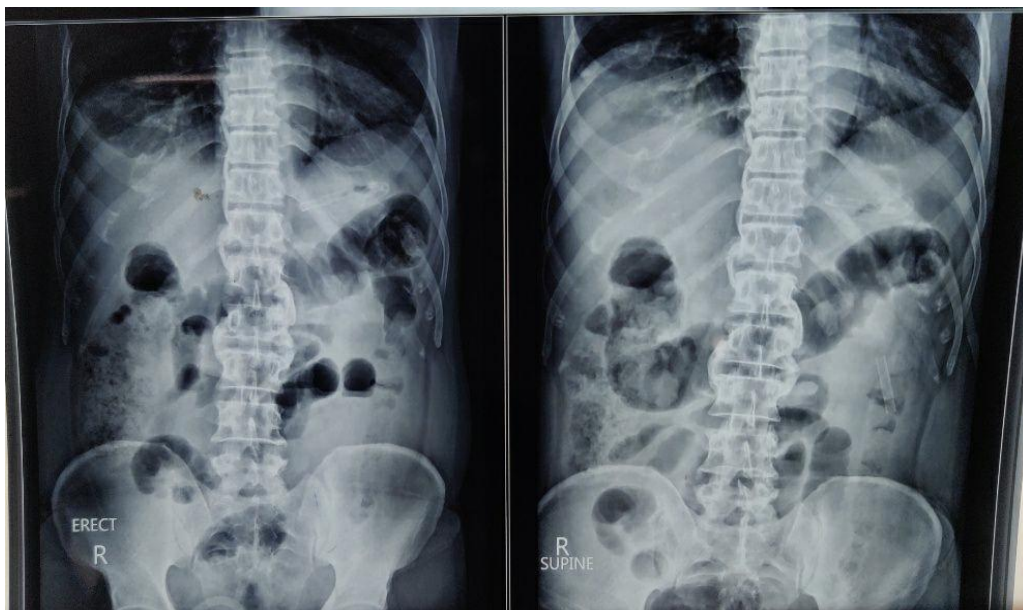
X-ray chest and abdomen of the patient showing a few dilated bowel loops
